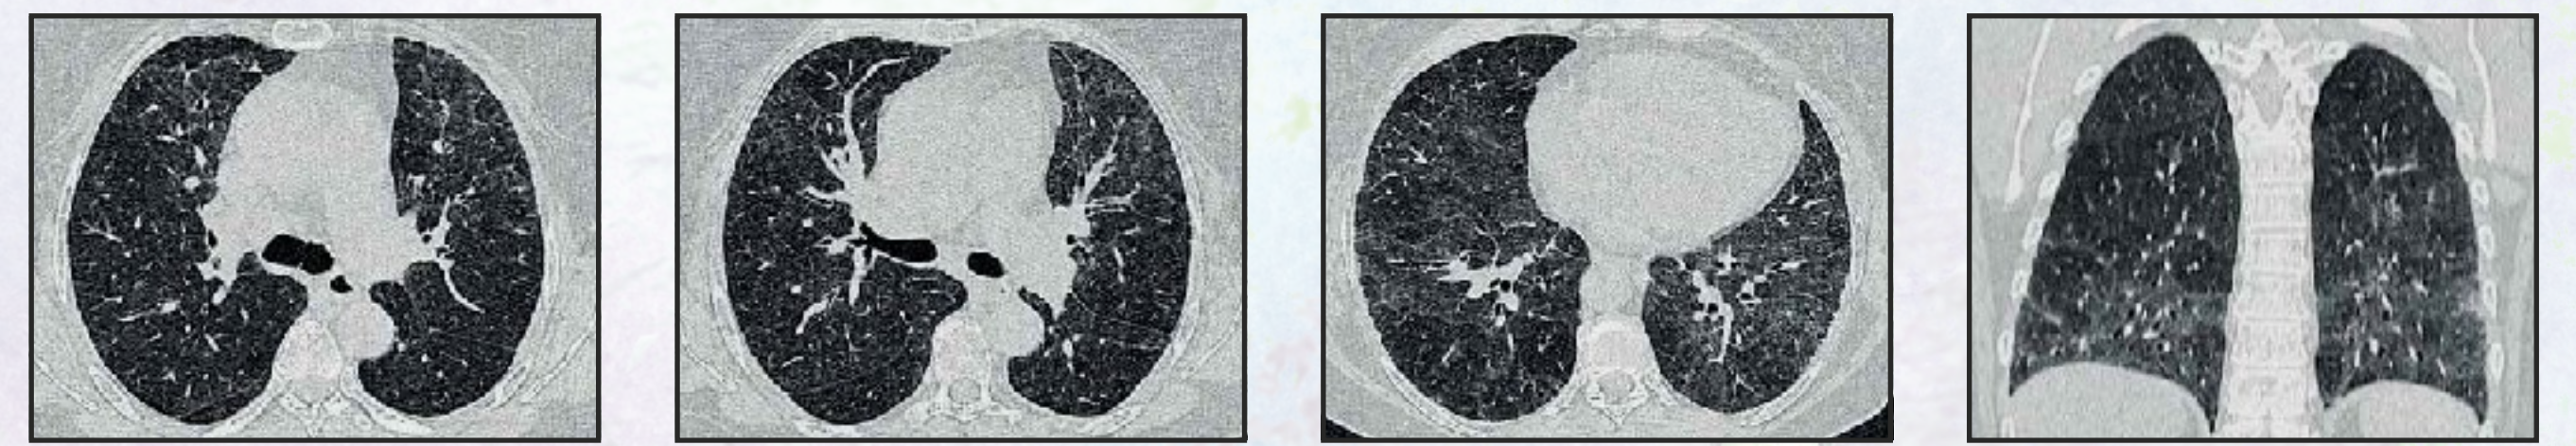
Image of acute pneumonitis as a drug-induced reaction to MTX. Initial CT scan in a 54-year-old female patient. Extensively confluent alveolar infiltration with starting reticular patterns, mainly in the basal region on both sides. Evidence of peripheral traction bronchiectasis as a sign of starting chronic interstitial infiltration.
